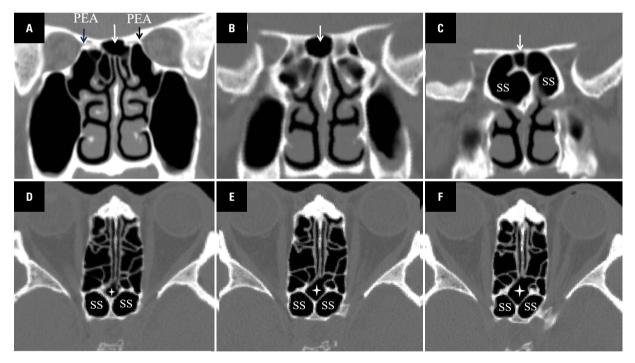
The location of the supraseptal posterior ethmoid cells (SPEC) in the coronal and axial plane of the computed tomography (CT) images. A series of coronal CT scans (A–C) showing that a cell (indicated by the arrow) lies to the posterior superior area of the nasal septum. An axial CT scan of the top-down series (D–F) showing the SPEC (indicated by the star) located between the two sphenoidal sinus (SS) and the perpendicular plate of the ethmoid bone. The SPEC is connected to the left posterior ethmoid and drains into it; PEA — posterior ethmoidal artery.
